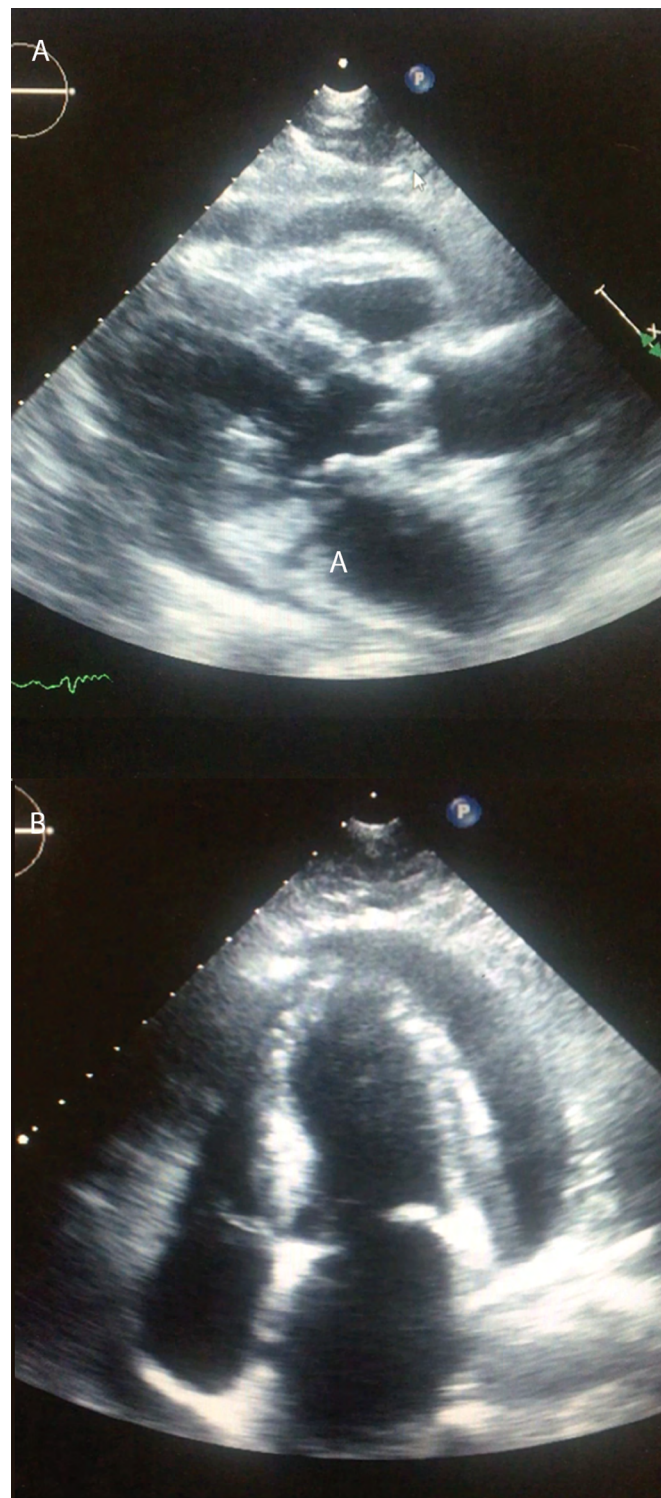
Parasternal long-axis (A) and apical four-chamber (B) views of a transthoracic echocardiogram, showing a moderate size pericardial effusion and vegetation of the aortic valve
